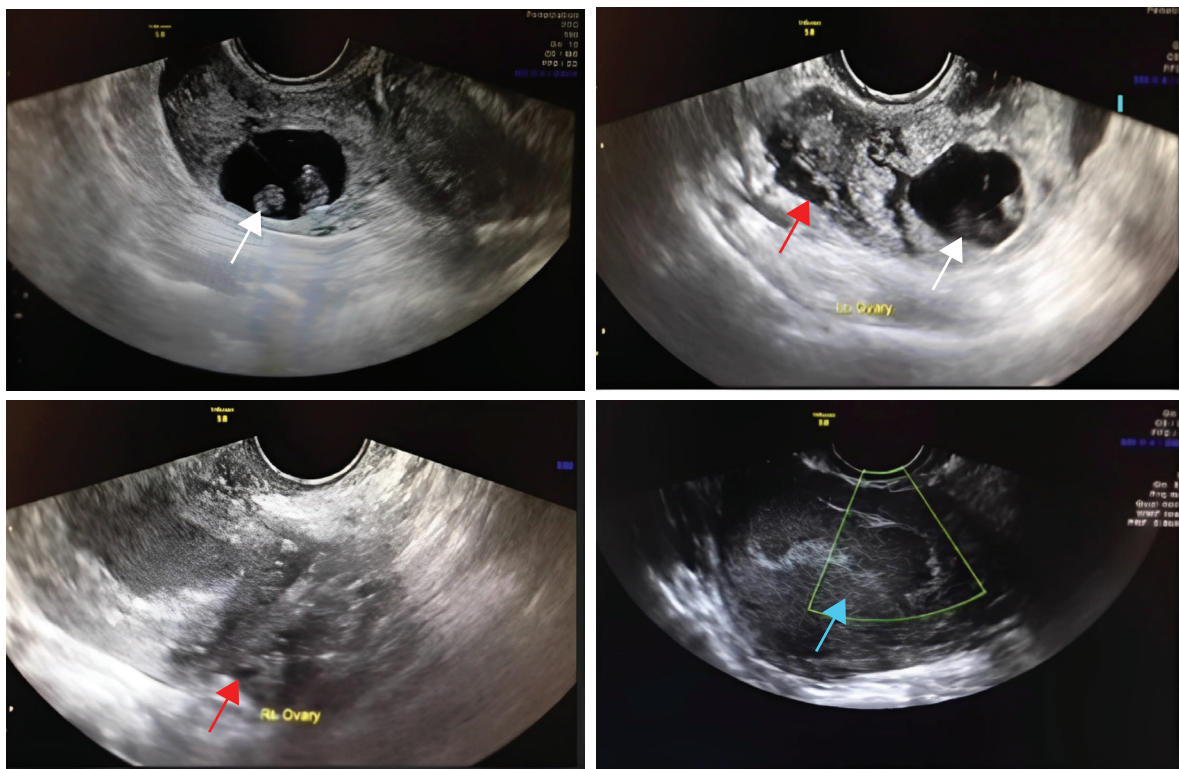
Transvaginal ultrasound depicts a left tubal twin pregnancy attached to the left ovary (white and red arrows, respectively). Doppler echo shows an absent fetal heart and surrounding free fluid (blue arrow).
